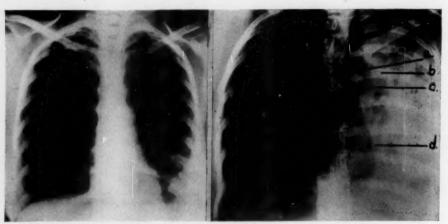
Case 3: Postero-anterior roentgenogram. A minimal tuberculous lesion is seen in the left lower lobe.
